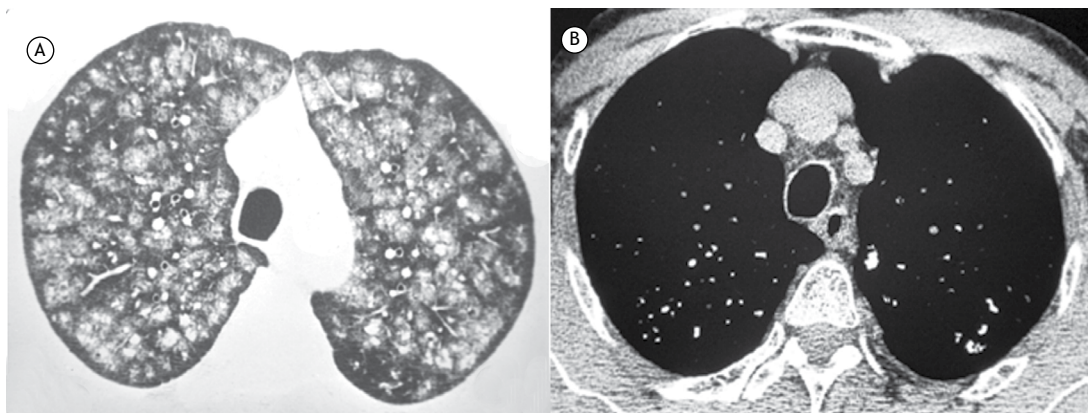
In A, axial CT scan of the chest with lung window setting at the level of the upper lobes shows nodular ground-glass opacities in a predominantly centrilobular distribution. In B, mediastinal window setting demonstrating small foci of calcification, corresponding to the ground-glass nodules.
